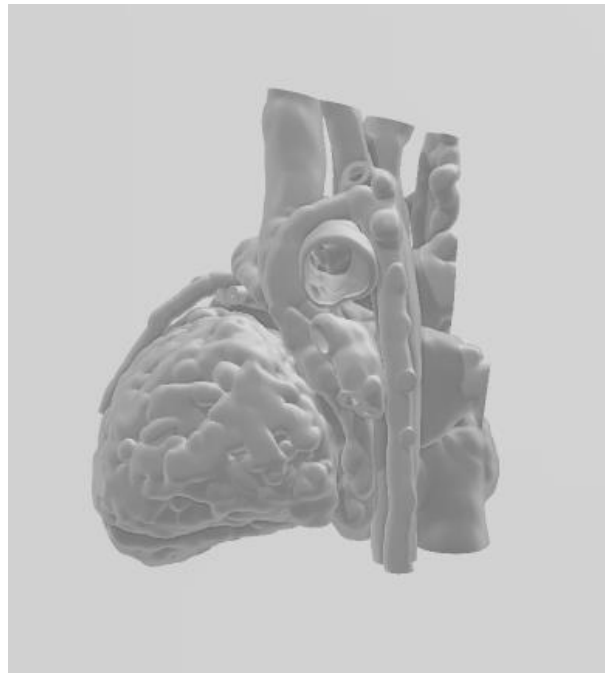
3D CHD model obtained from an anonymised CT angiogram.
